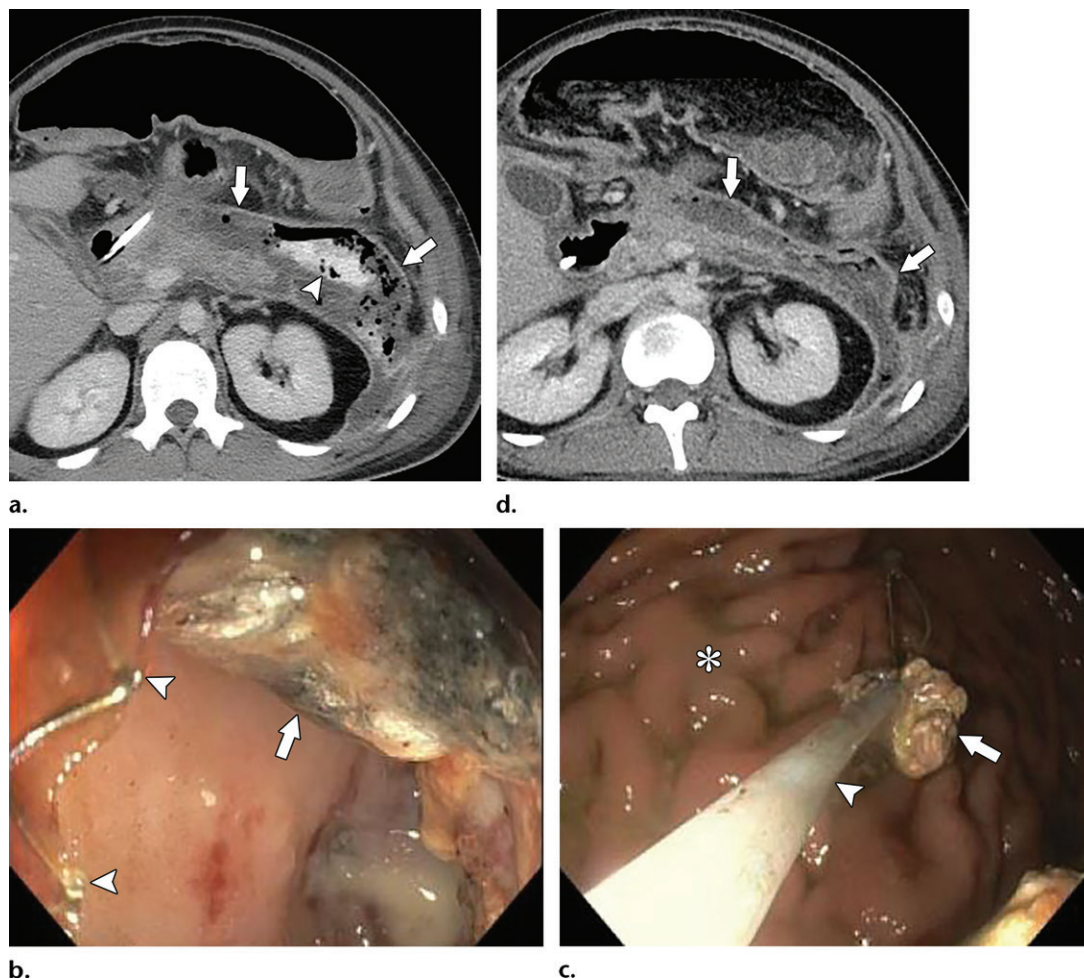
Step-up approach in a 27-year-old man with sepsis and severe alcoholic pancreatitis complicated by a large WON. (a) Axial contrast-enhanced CT image obtained 4 days after ETD with cystogastrostomy and LAMS placement (not shown) shows a persistent large complex WON in the peripancreatic space (arrows). Areas of high attenuation (arrowhead) represent oral contrast material passing into the collection from the stomach. (b) Endoscopic image obtained during necrosectomy looking into the WON through the LAMS (arrowheads) shows focal necrotic material (arrow) along the wall of the collection. (c) Endoscopic image shows necrotic material (arrow) being removed piece-meal by grasping with a snare (arrowhead) and retracting into the stomach (*). (d) Axial contrast-enhanced CT image obtained 1 week later shows decreased size of the necrotic collection (arrows) after necrosectomy.
